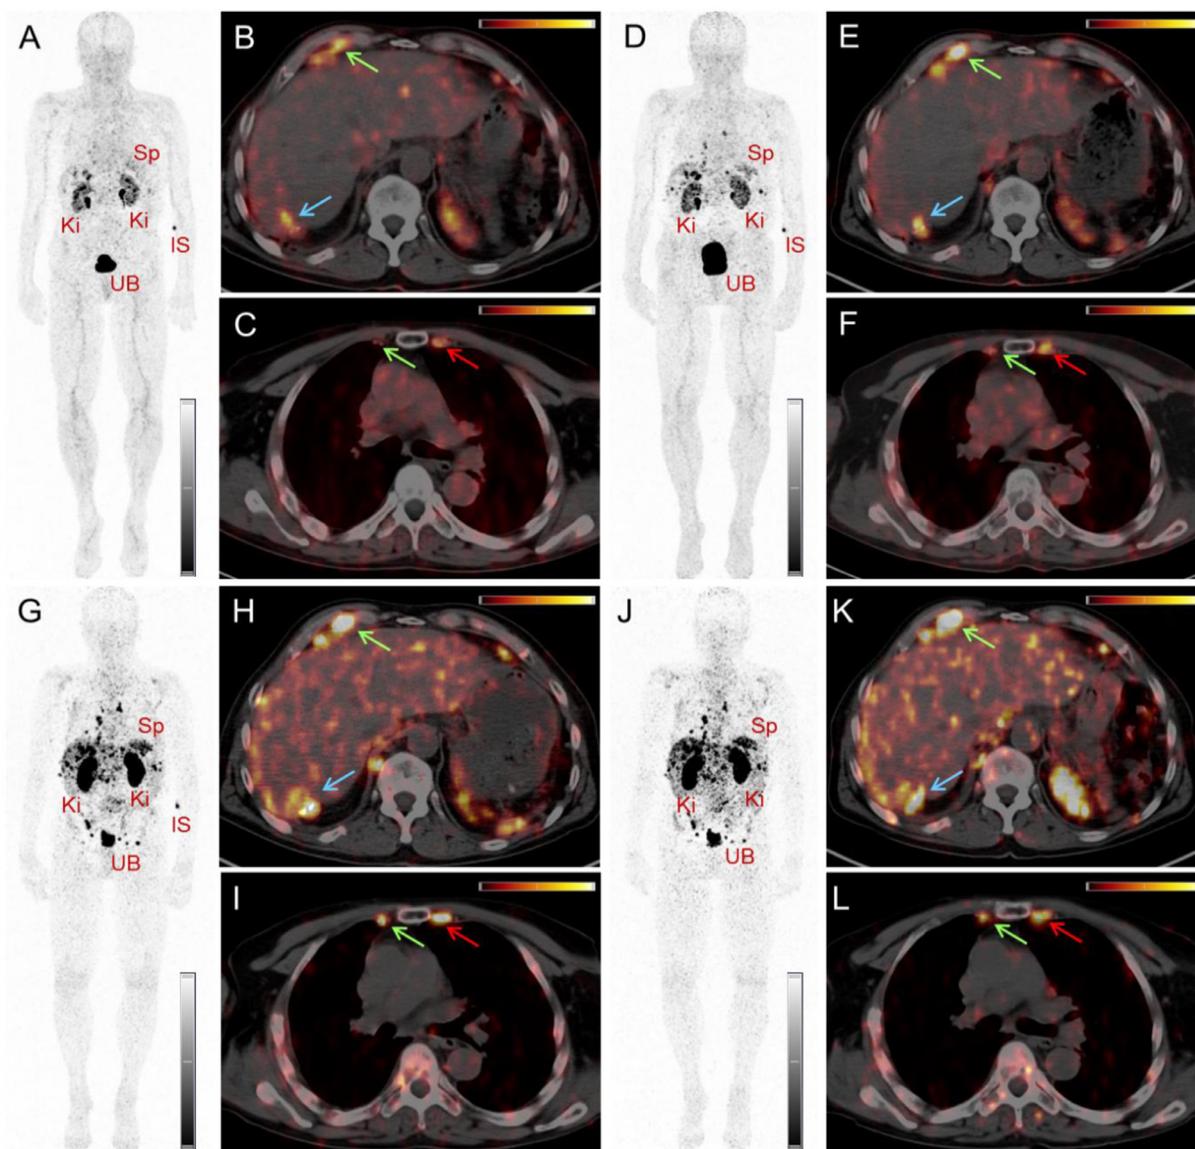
PET/CT images of a patient with neuroendocrine neoplasm of the terminal ileum obtained at 25 minutes (A-C), 2 hours (D-F), 17 hours (G-I), and 24 hours (J-L) after injection of Tb-152 DOTATOC, respectively. (A, D, G, J) Maximal intensity projection (MIP) images show the kidneys (Ki), the urinary bladder (UB), the spleen (Sp), and the injection site (IS); (B, C, E, F, H, I, K, L) transverse sections of PET/CT fusion images demonstrate radiopeptide uptake in lymph nodes metastases in the right costophrenic region and right internal mammary chain (green arrows), as well as in segment 7 of the liver (blue arrows) and in a skeletal metastasis in the left third rib adjacent to the sternocostal junction (red arrows). UB, urinary bladder; SI, site of injection; Ki, kidneys; Sp, spleen. (Image reproduced from Baum et al.⁸⁴)
